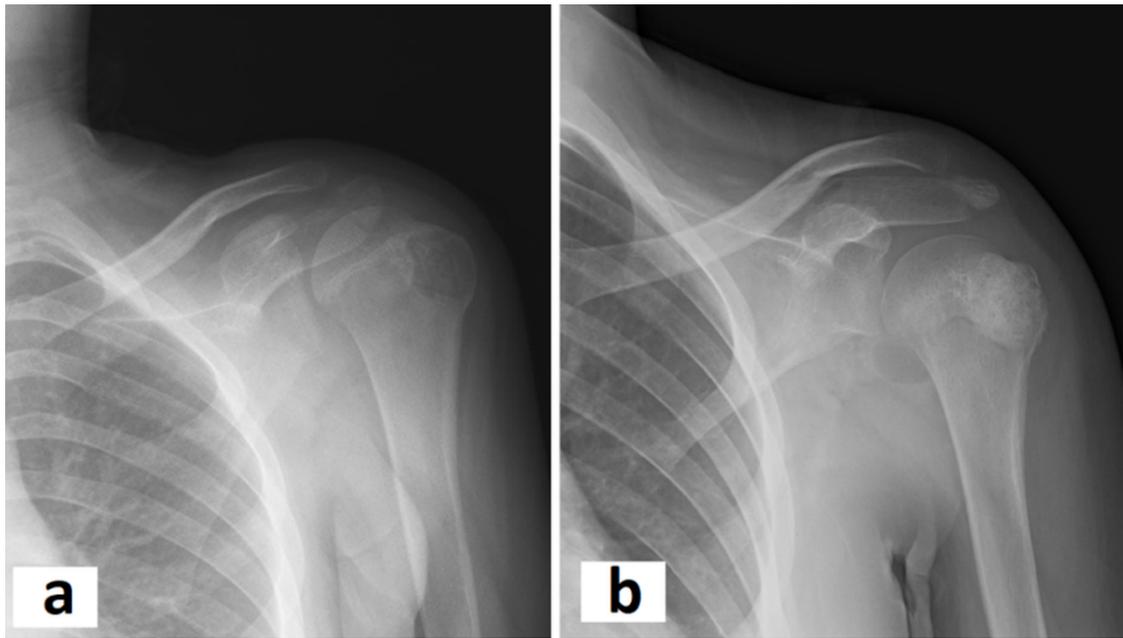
Curettage and bone grafting of a chondroblastoma of the left proximal humerus in an 14-year-old girl (2a:preoperative radiography, 2b:postoperative radiography).
